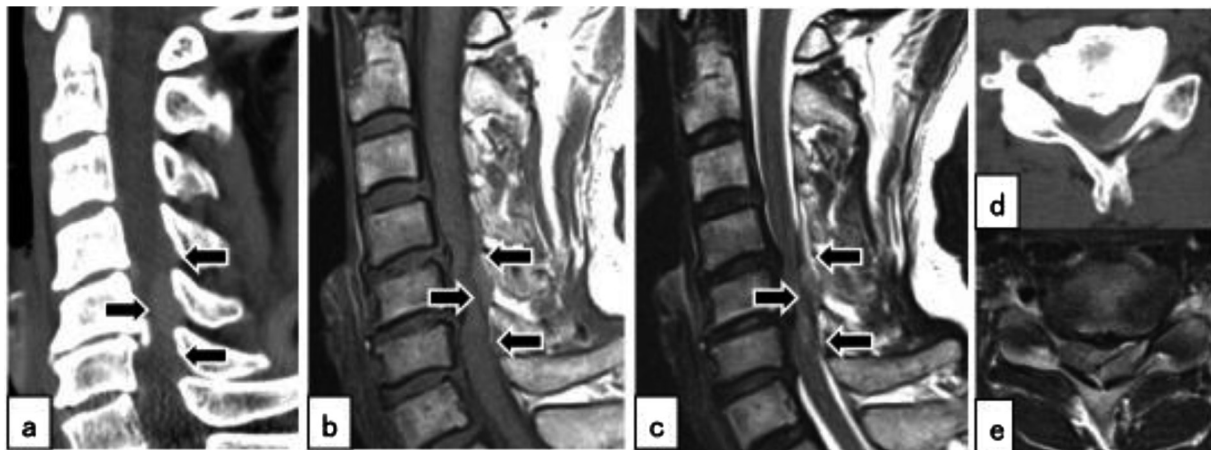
Case 7. (a) Computed tomography (CT) scan (sagittal view) showing a spindle-shaped mass lesion at the C4–C6 level (arrows). (b, c) Mixed intensity observed on T1- and T2-weighted magnetic resonance imaging (MRI) scans indicates a hematoma (arrows). (d, e) Axial CT and MRI scans showing an epidural hematoma at the left portion dorsal to the dural sac.
